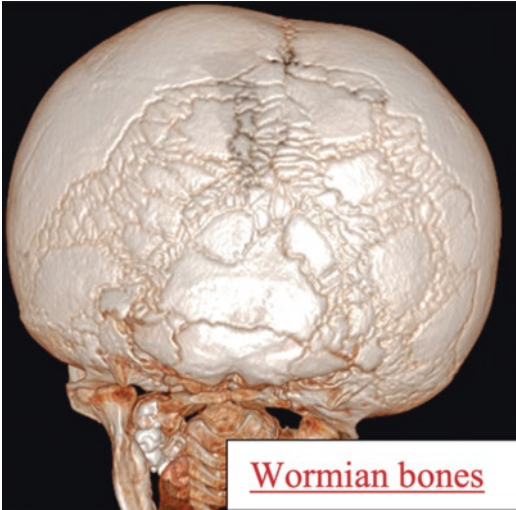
3D Reformatted CT scan of the skull showing multiple Wormian bones within the lambdoid sutures
